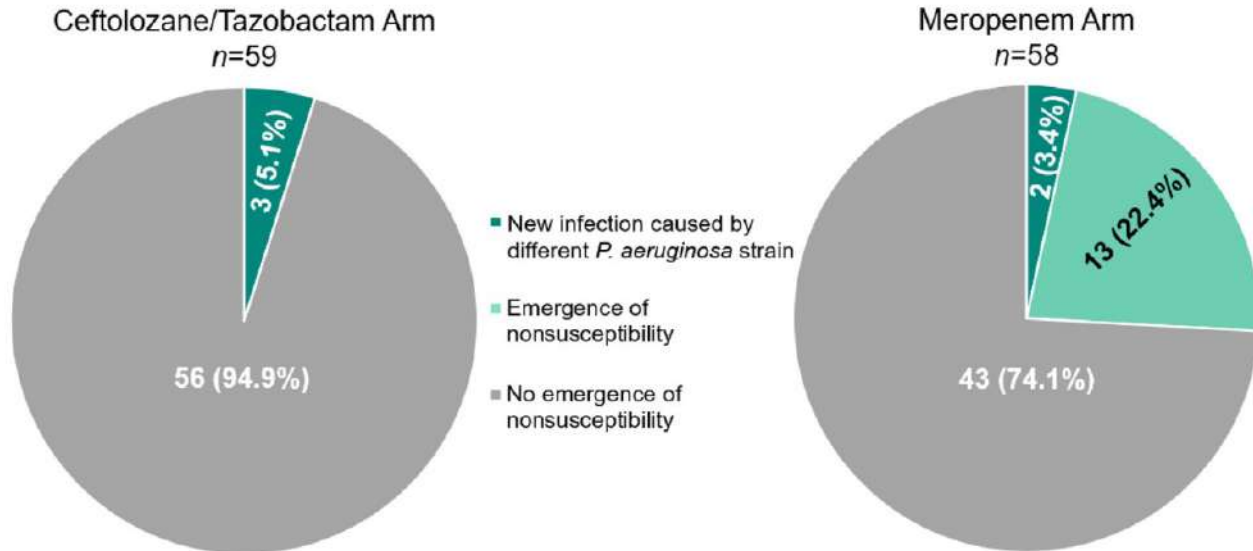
Comparison of rates of emergence of nonsusceptibility in baseline susceptible *Pseudomonas aeruginosa* isolates in ASPECT-NP.
